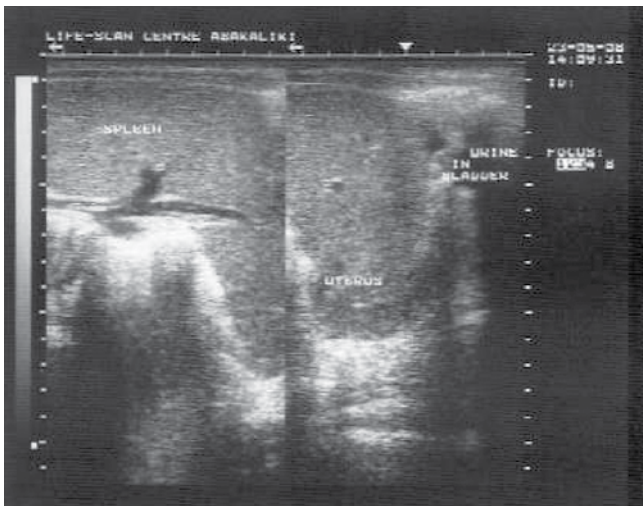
A dual B-mode (ultrasound) display of the abdomen and pelvis showing the spleen, uterus and urine in the urinary bladder
